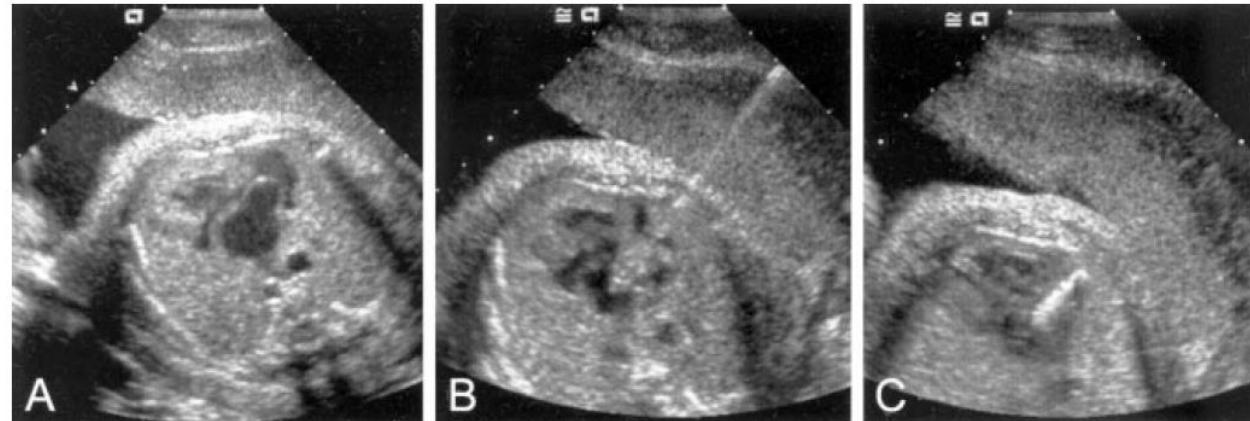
A–C, Transabdominal ultrasound image of heart in 1 fetus with dilated left atrium and thin, bulging atrial septum before atrial septal puncture (A), during septal puncture with Chiba needle (B), and during dilation with 3-mm coronary angioplasty balloon (C).
